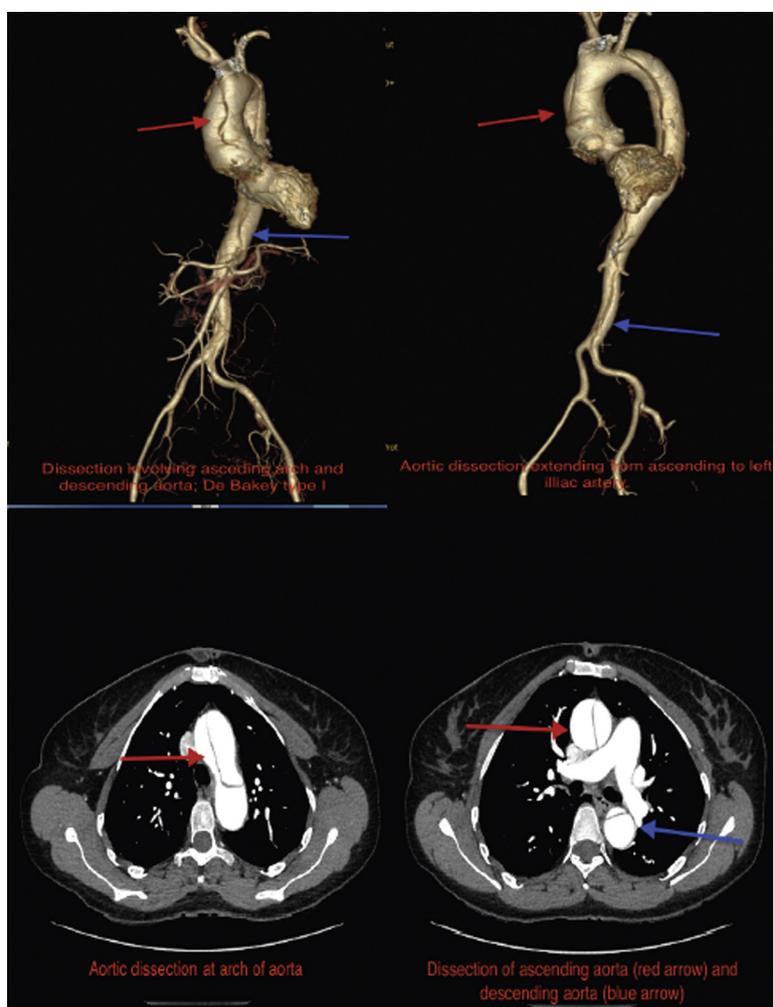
(A) Multi-detector 256 slice computed tomography 3D re-constructed contrast aortogram image showing dissection of ascending aorta (red arrow) and descending aorta (blue arrow). (B) Multi-detector 256 slice computed tomography 3D re-constructed contrast aortogram showing dissection of the ascending aorta (red arrow) and descending abdominal aorta up to left iliac artery. (C) Multi-detector computed tomography contrast cross-sectional scan showing dissection involving the arch of the aorta (red arrow). (D) Multi-detector computed tomography contrast cross-sectional scan demonstrating dissection of ascending aorta (red arrow) and the descending aorta (blue arrow) at the level of the pulmonary artery bifurcation.
